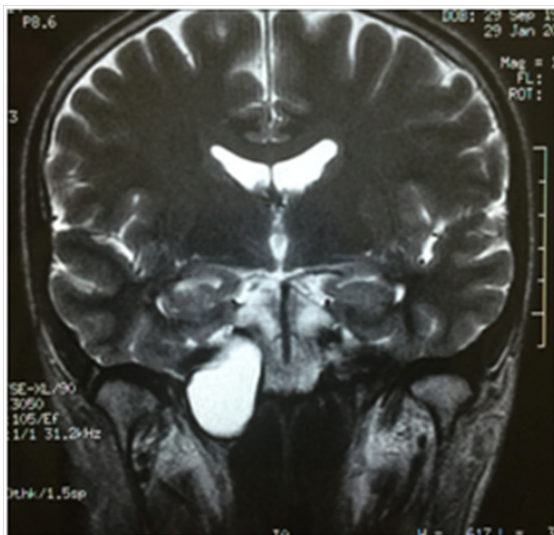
A large expansile lesion is noted in the right petrous apex, hyperintense on both T1- and T2-weighted scans, without diffusion restriction or internal contrast enhancement.
